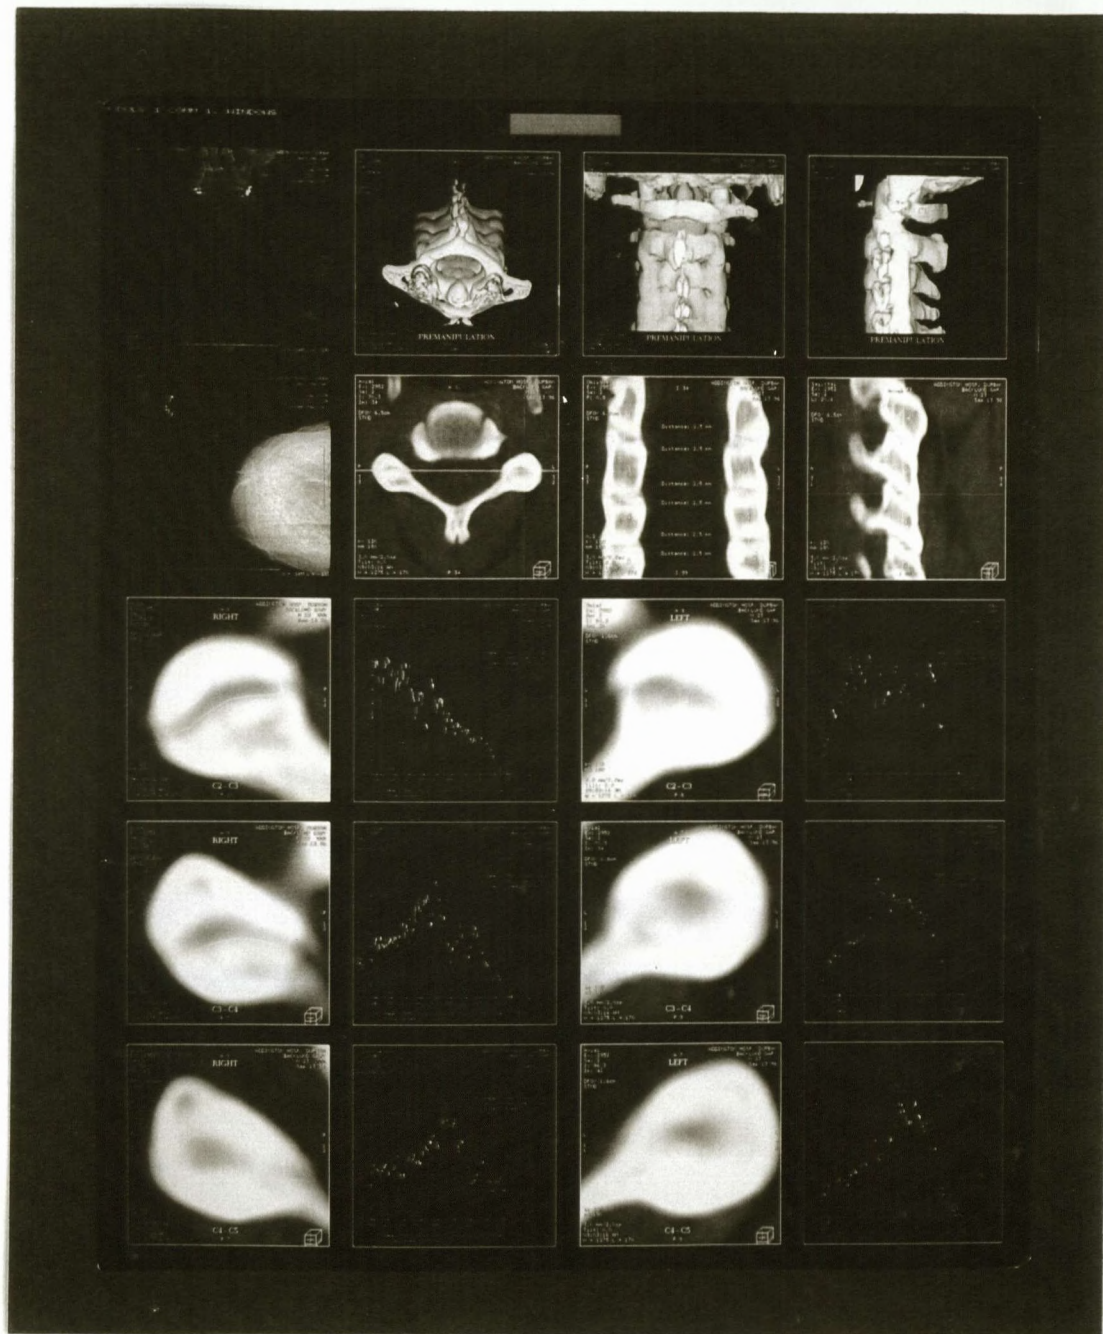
Experiment 6 : Pre-manipulation + 15kg traction CT scan
